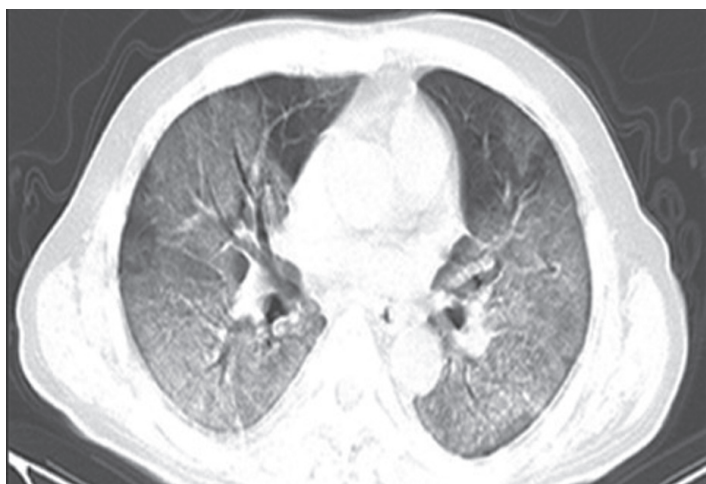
Belizean patient confirmed with COVID-19. Axial CT image. Extensive bilateral basilar ground glass opacity (GGO) associated with bronchovascular thickening.
